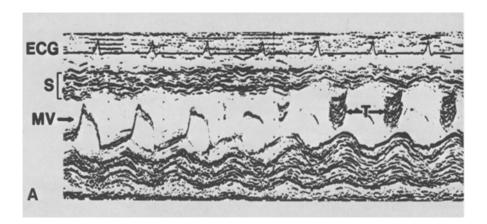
Right ventricular myxoma in a patient who earlier had a left atrial myxoma and would later present with a right atrial myxoma. A Echocardiogram showing multiple echoes in the right ventricular outflow tract (RVOT) indicating a tumor. B Echocardiogram at the level of the mitral valve demonstrating myxoma (MYX) in the right ventricle. C Echocardiogram of the anterior tricuspid leaflet (TV). AL, aortic leaflets, PM, posterior mitral leaflet, RV, right ventricle, RA, right atrium, LA, left atrium.
